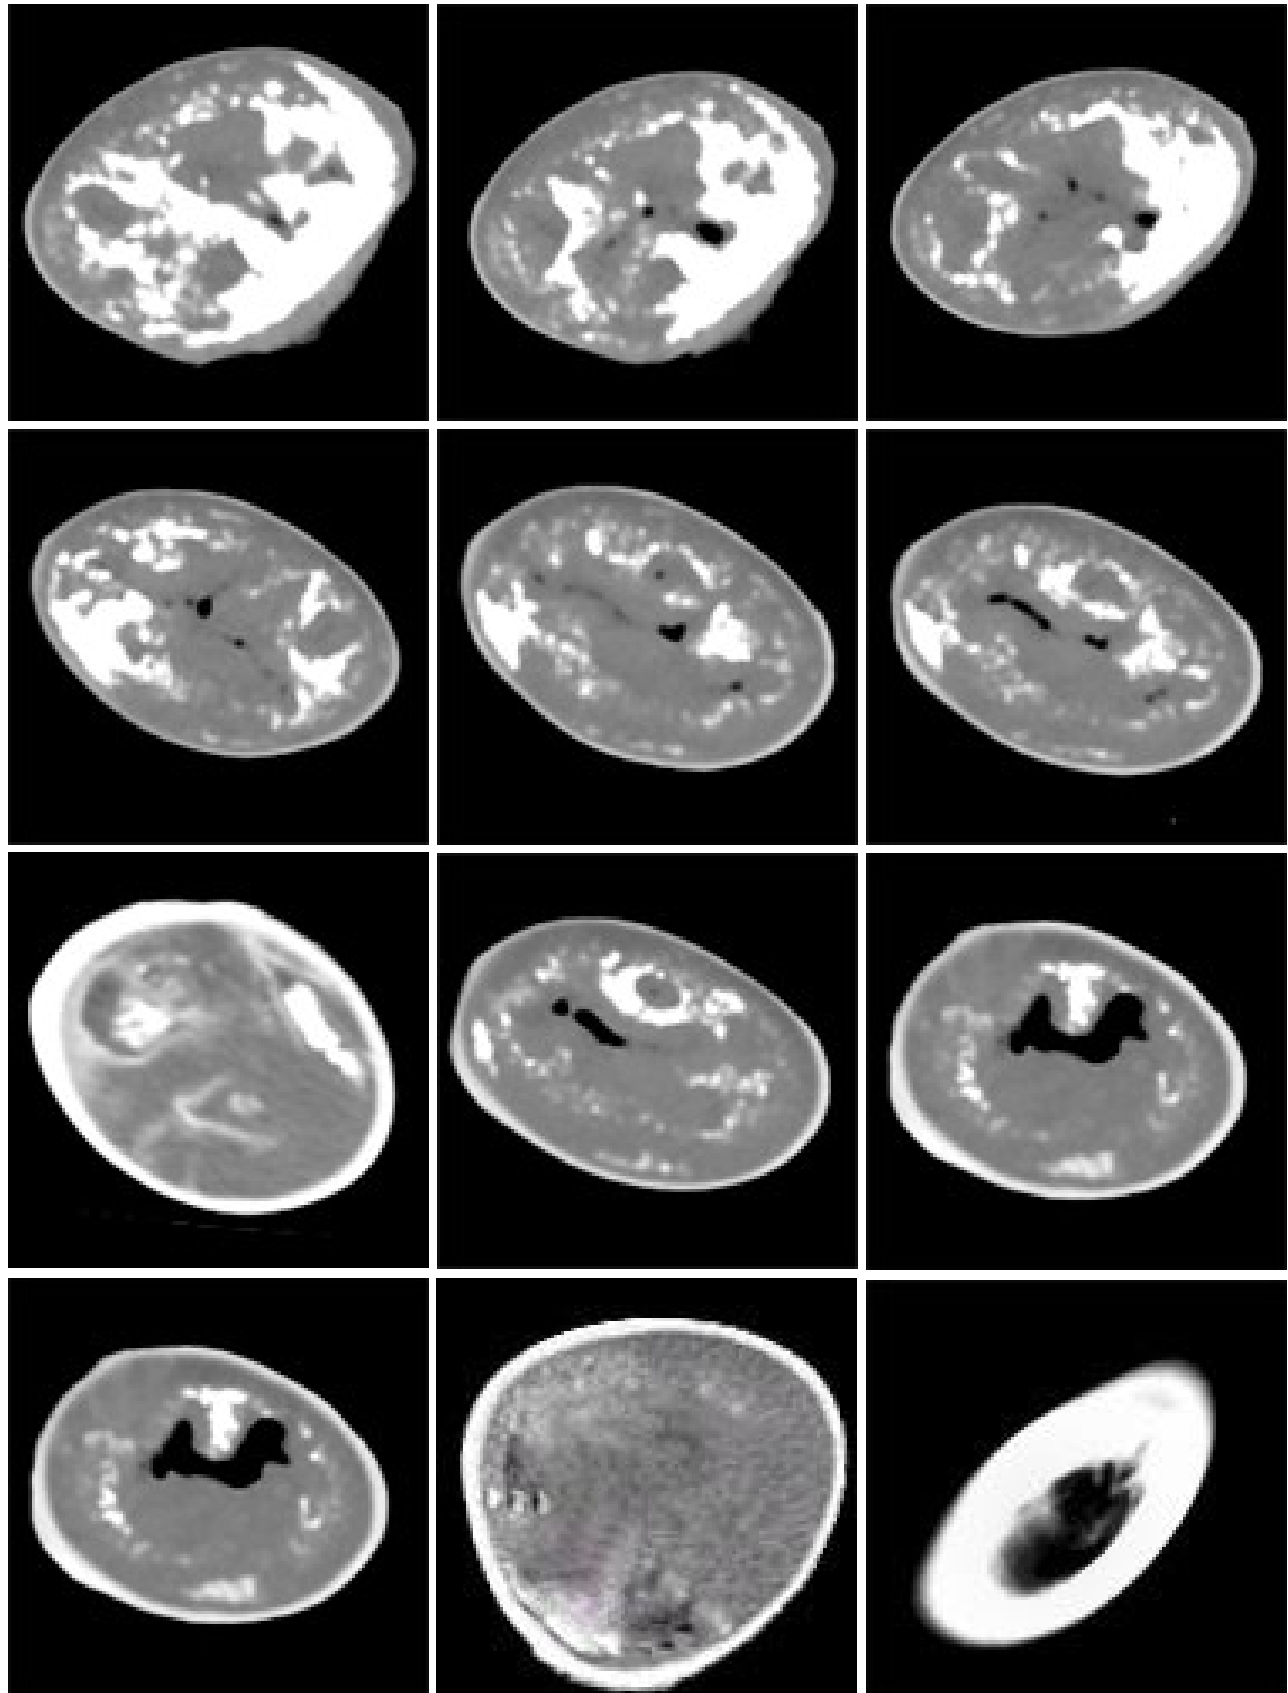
CT images (Transverse slices) of cancerous horn from base to apex indicating osteolytic bony fragments at base of horn. Greyish pneumatic cavity indicating presence of neoplastic mass and complete osteolysis of horn core.
